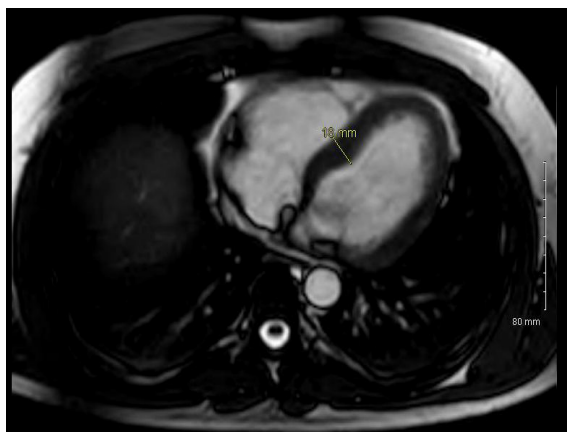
Cardiac MRI demonstrating LVH with septal thickness of 18 mm.
